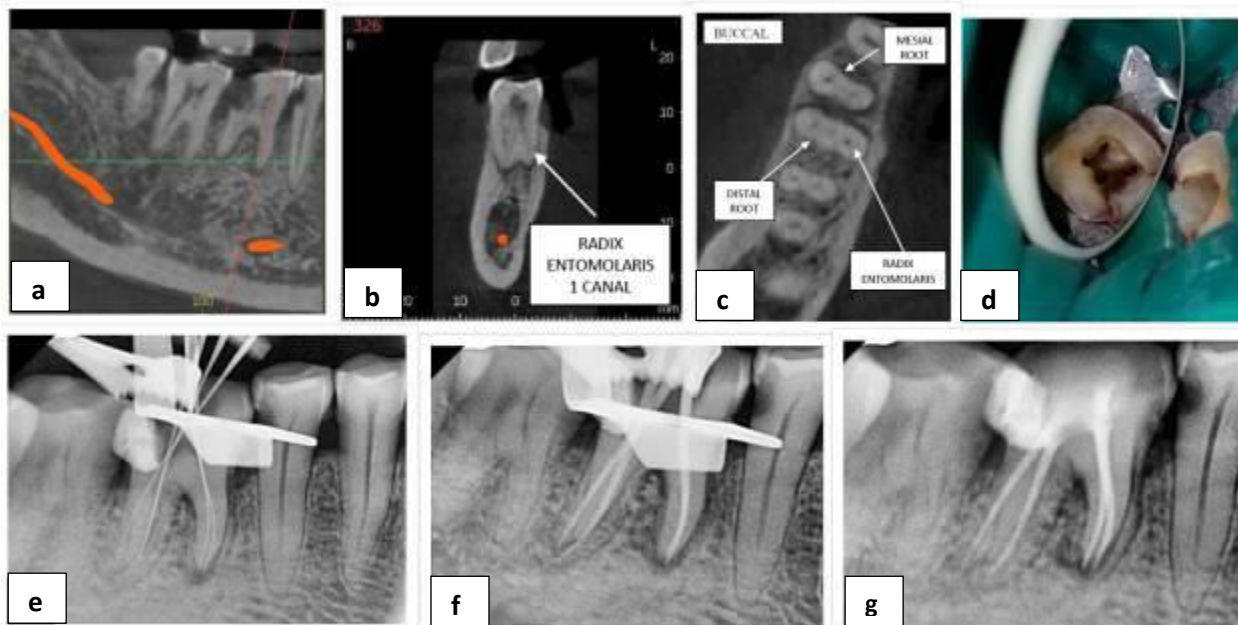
(a) CBCT cross section irt #46 (b) CBCT Cross Section - Distal Root + Radix Entomolaris irt 46 (c) CBCT axial section irt #46 (d) clinical photograph irt #46 (e) working length radiograph irt #46 (f) mastercone radiograph irt #46 (g) postendodontic restoration irt #46
